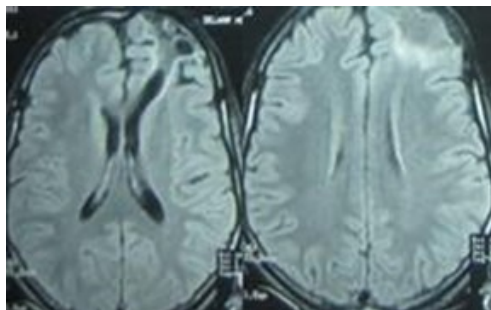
MRI of brain axial views showing post-traumatic left fronto-polar gliosis causing drug-resistant focal seizures. Source: Figure by authors.
